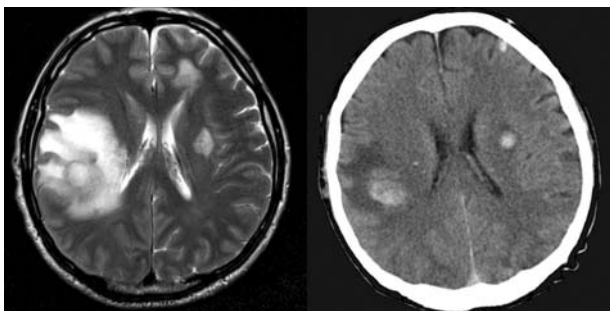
MRI and CT scan with multiple metastases
